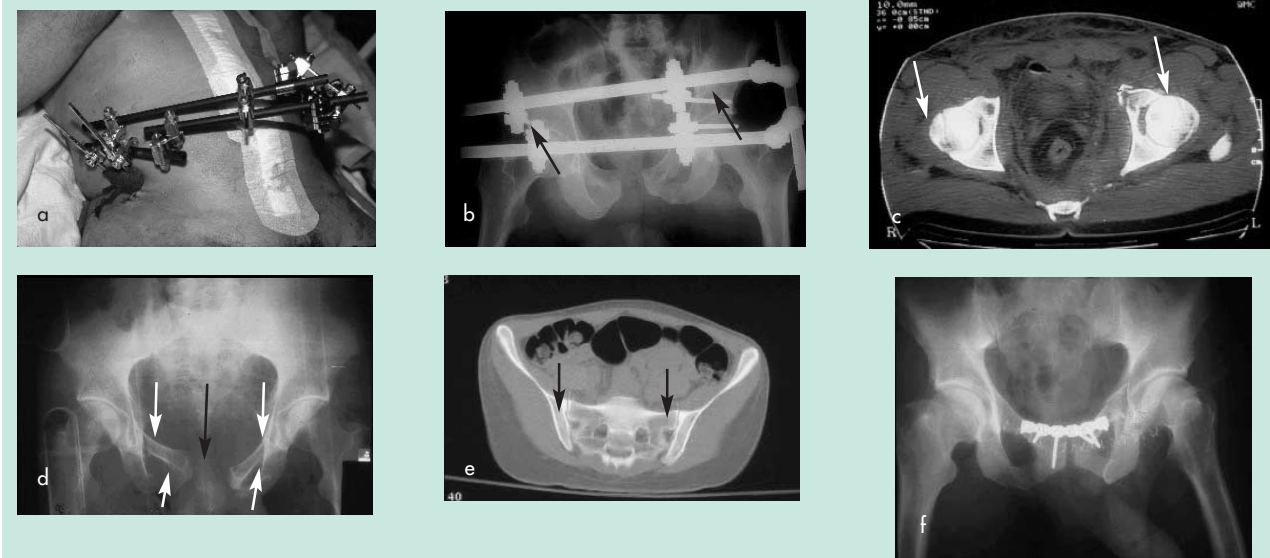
a. The preferred 'high' application of a pelvic external fixator device. b. The 'low' approach is to be avoided unless the technique is undertaken in theatre with image intensifier control. Note the bilateral femoral head penetration by the external fixator pins. c. A computed tomography scan confirms femoral head penetration by the external fixator pins. d. A pelvic 'pseudo-diastasis' (black arrow) may be misleading. The symphyseal diastasis is associated with fractures of all four pubic rami (white arrows). There is no disruption of the posterior pelvic ring and no external fixator is required. This fracture is typically caused by a motorbike's petrol tank. It is not usually associated with haemorrhage. e. A computed tomography scan confirms that no disruption of the posterior pelvic ring has occurred. f. A pseudo-diastasis may be treated with an anterior reconstruction plate in order to restore normal anatomy. The application technique is outlined in Table 2.
